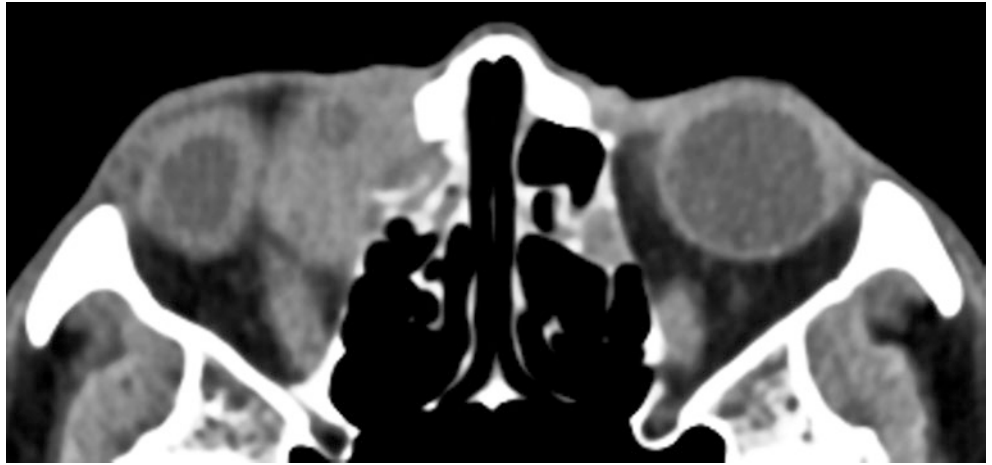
Coronal CT scan showing a right lacrimal sac malignancy with bony destruction in the vicinity and extension into orbits and nasal cavity
